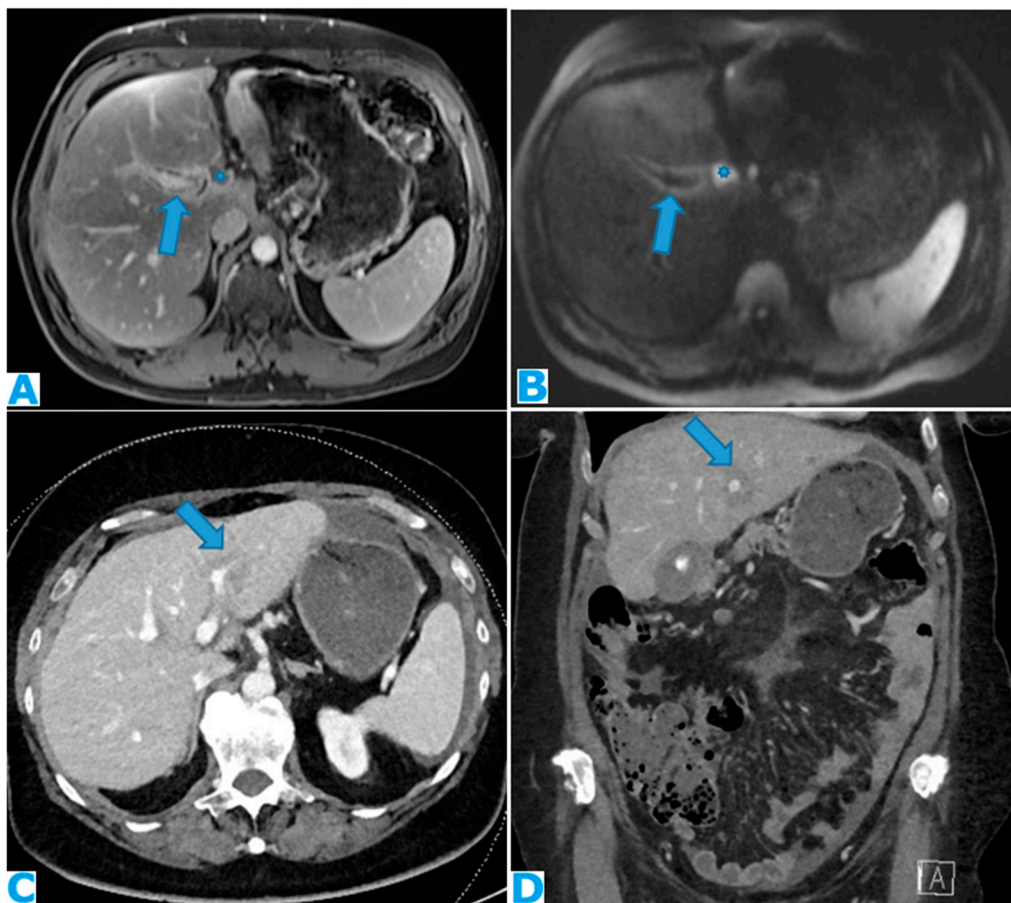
DWI (A), axial CE portal phase FST1WI (B). PC from colon carcinoma: deposits within the periportal space. Observe the diffusion restriction and enhancement around the periportal space (arrows); also note the nodular deposit (*). Axial CE-CT(C) and coronal MPR (D). PC from ovarian carcinoma: Note the periportal deposit as a soft tissue mass around the left portal branch, more conspicuous on the MPR.
